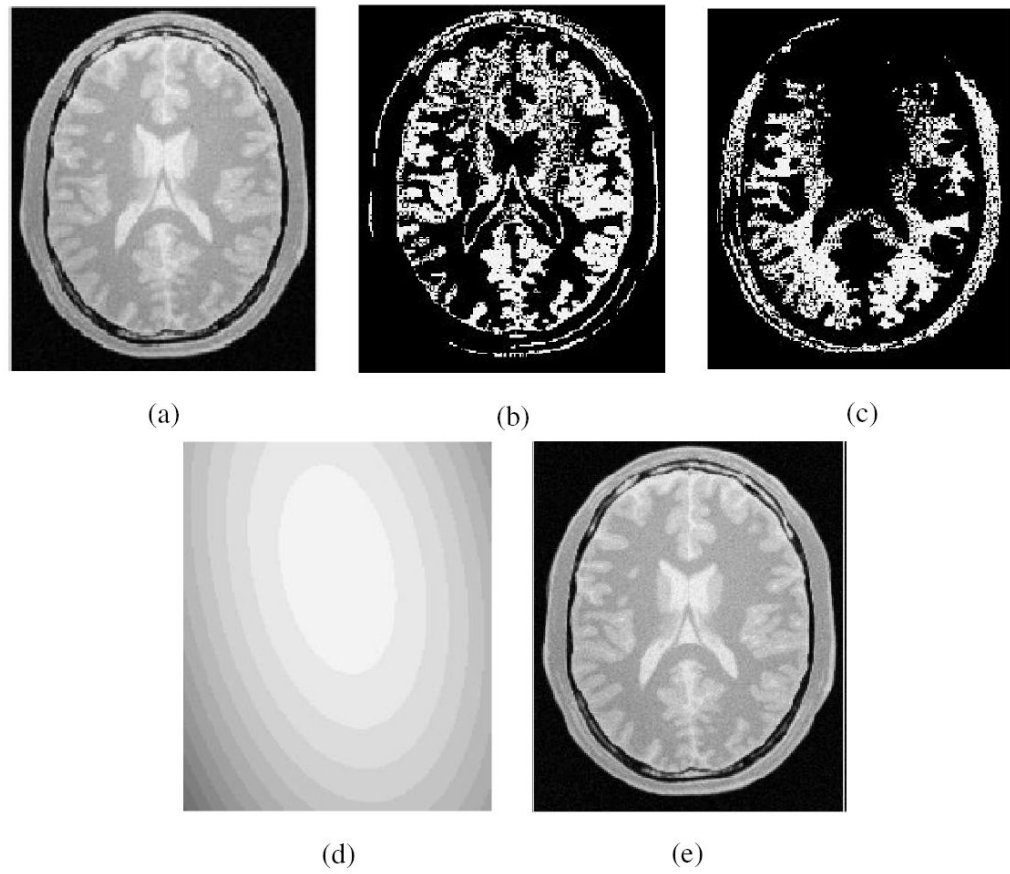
(a) One slice of the original PD-weighted MRI. (b) GM region and (c) WM region resulting from thresholding this slice with fixed intensity intervals; (d) corresponding slice of C_{be} ; (e) corresponding slice of corrected scene C_c .
